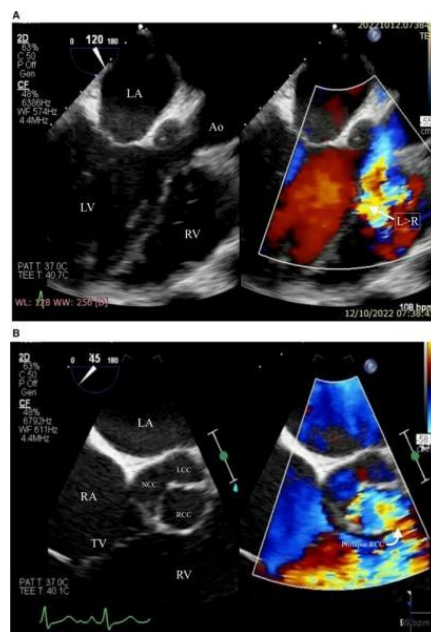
Transesophageal echocardiography confirmed rupture of the sinus of valsalva aneurysm on the Right coronary cusps (RCC). A and B Images taken flow from the RCC to the right ventricle on color doppler (arrow). Ao=aorta; RV = Right ventricle; LV = left ventricle; LA = left atrium; L = left; R = right; TV = tricuspid valve; NCC = non-coronary cusp; LCC=left coronary cusp; RCC=right coronary cusp.
